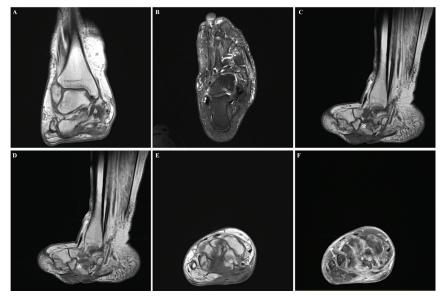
MRI 7 months after surgical debridement and filling the bone void with gentamicinloaded CaS/HA. A: T1 weighted, turbo spin echo (TSE) sequence, coronal view. Decrease of low signal intensity areas in soft tissues and osseous structures when compared with preoperative MRI. B: T2 weighted, TSE, fat suppression (FS), transversal view. No high signal intensity areas in osseous structures representing no residual areas of bone marrow oedema and a minor area of high signal intensity in the soft tissues representing oedema. C: T1 weighted, TSE, pre-gadolinium contrast sagittal view and D: post-gadolinium sagittal view. Decreased low signal intensity area in the soft tissues. The decrease of signal intensity of the navicular bone (marked with *) after gadolinium contrast suggest some degree of sclerosis. E: T1 weighted, TSE, coronal view. Fibrous tissue is shown on the plantar aspect of the foot with oedema in the central compartment of the foot. The reduction in signal intensity of the medial cuneiform bone (marked with *) suggest postoperative osseous oedema. F: T1 weighted, TSE, FS, post-gadolinium contrast, coronal view. Persistent gadolinium uptake in the soft tissue and medial cuneiform bone (marked with *) suggests postoperative oedema.
